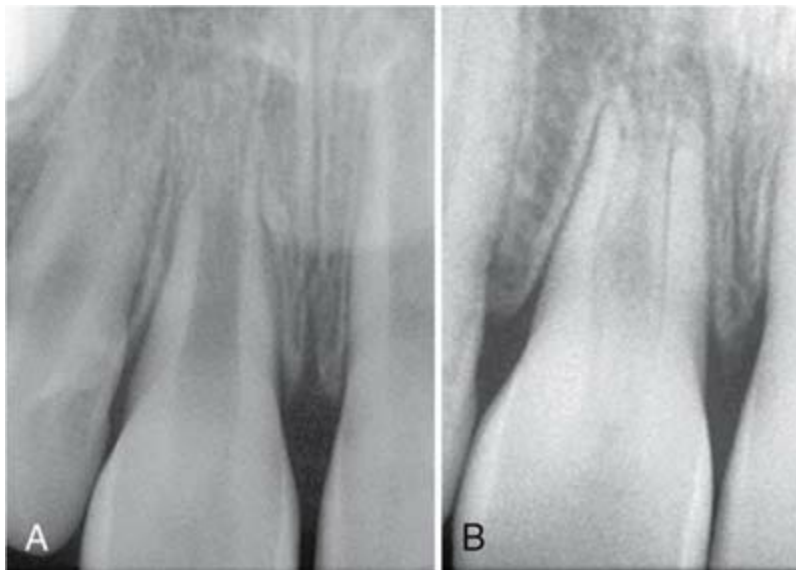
Revascularization of immature root. A tooth with an open apex was replanted soon after the avulsion. The checkup radiograph 12 years later confirms that regrowth has taken place into the pulp chamber. It appears that a bone plug has grown in, and new periodontal ligament has formed, with a lamina dura within the pulp canal.
